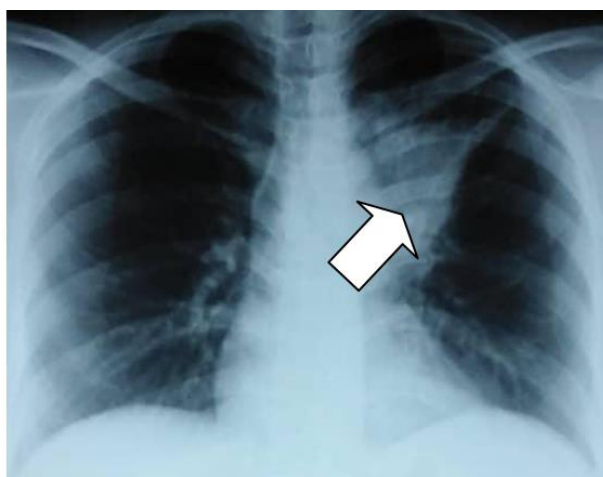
Chest Radiographs during the first admission
